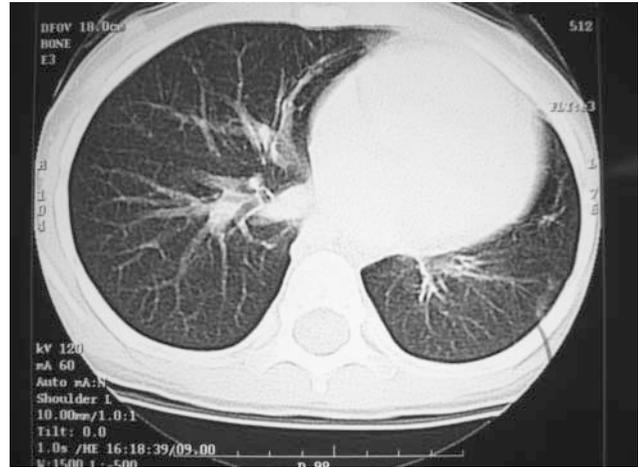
CT thorax reveals small left lower and lingular lobe with minimal interstitial lung markings (Case 1).
